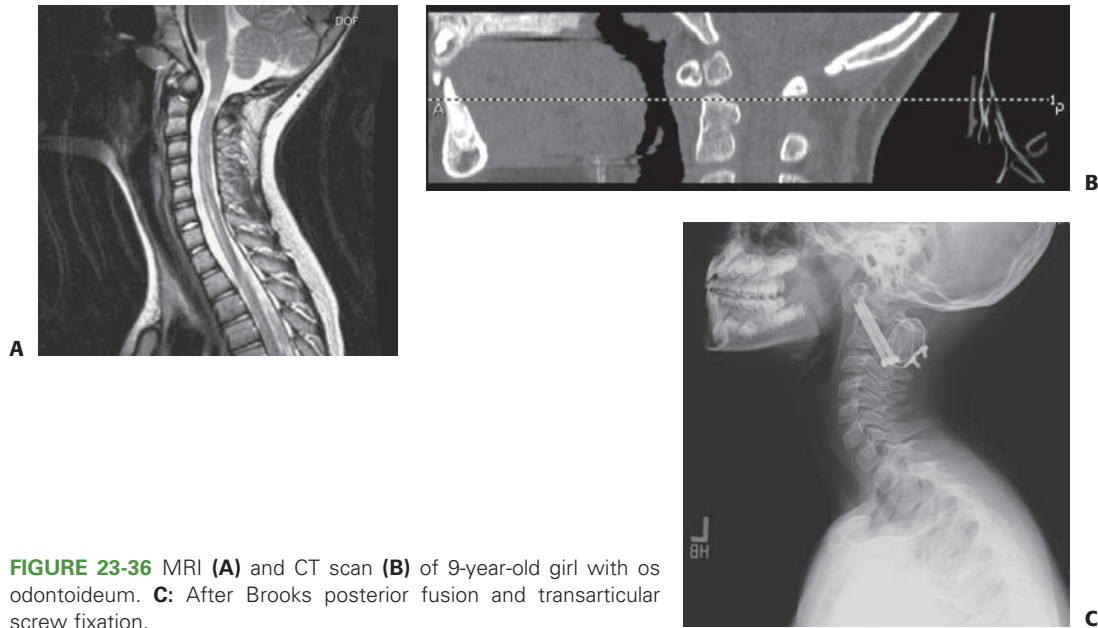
MRI (A) and CT scan (B) of 9-year-old girl with os odontoideum. C: After Brooks posterior fusion and transarticular screw fixation.
